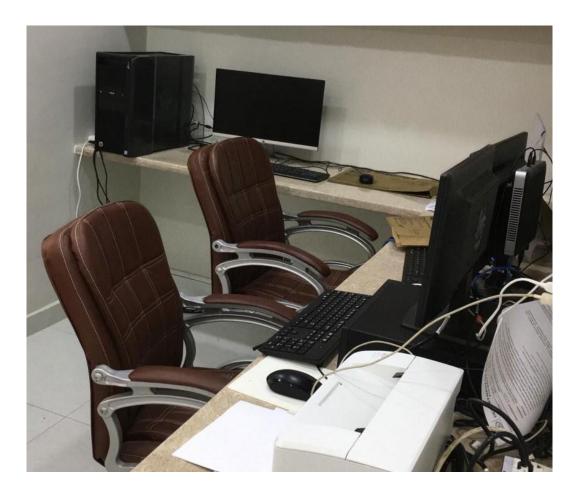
CT scan reporting room (PNS-Shifa Hospital Karachi)
